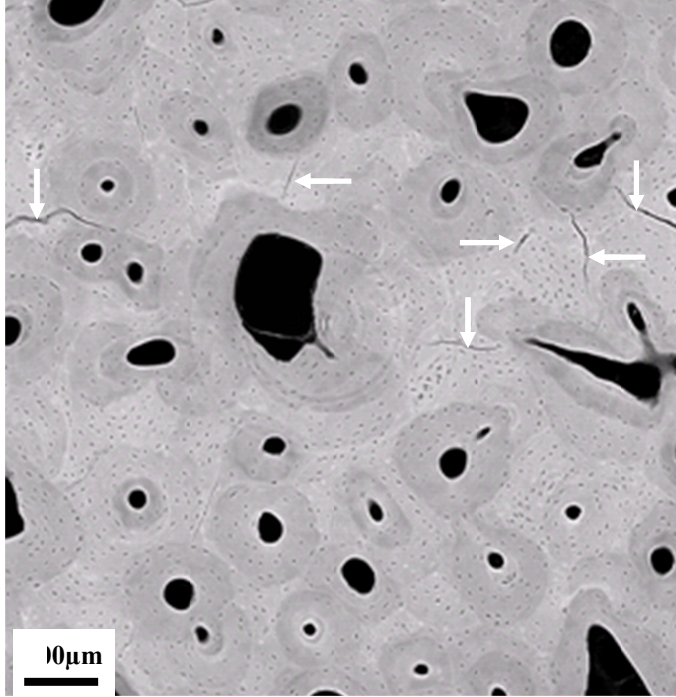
Transverse 2-D high resolution μ CT cross-section with microcracks (white arrows)
